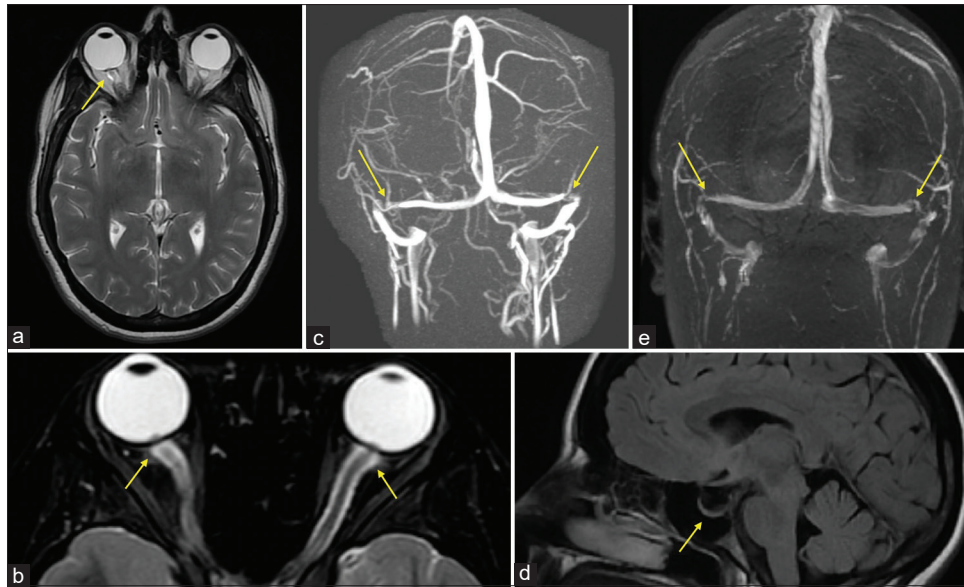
MRI findings suggestive of elevated intracranial pressure: (a and b) Distention of the optic nerve sheath with posterior globe flattening and protrusion of the optic nerve into the globe (yellow arrows); (c and e) stenosis of the transverse-sigmoid sinus junctions (yellow arrows); (d) pituitary flattening (yellow arrow)
